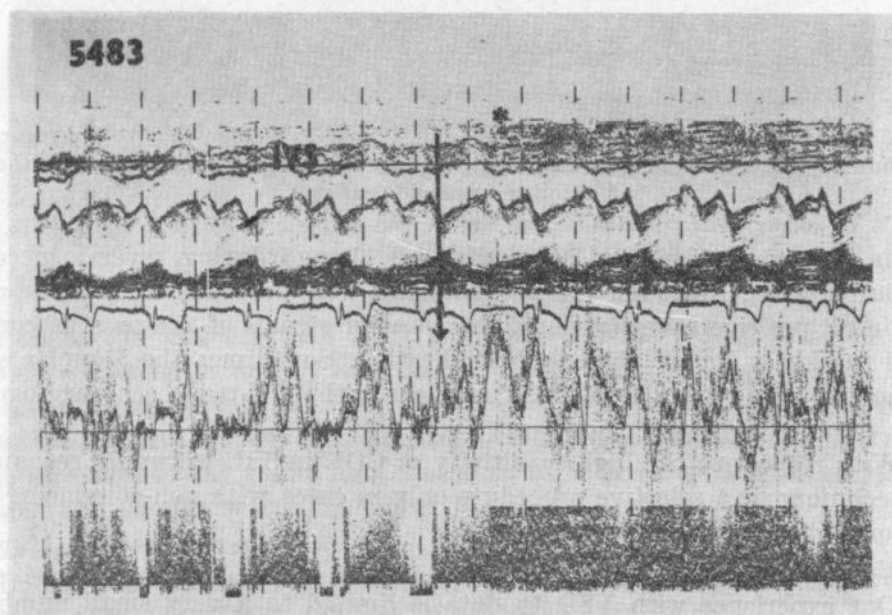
Ventricular septal defect. The Doppler tracing changes due to the microbubbles entering the left ventricular outflow tract (see arrow). Doppler sampling performed in the left ventricular outflow tract, close to the left septal border. (IVS... septum, asterisk indicates the contrast within the right ventricle)
